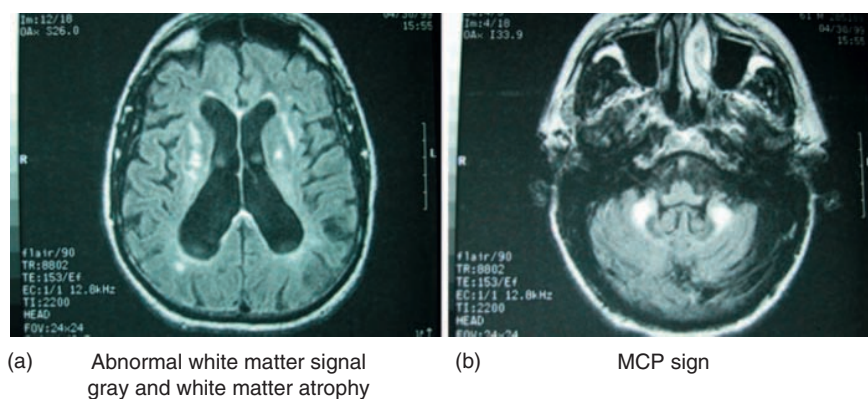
MRI findings on FLAIR images in FXTAS showing MCP sign, abnormal cerebellar white matter signal, and cerebellar atrophy (a), and increased signal in deep white matter and volume loss in the cerebral hemispheres (b).
